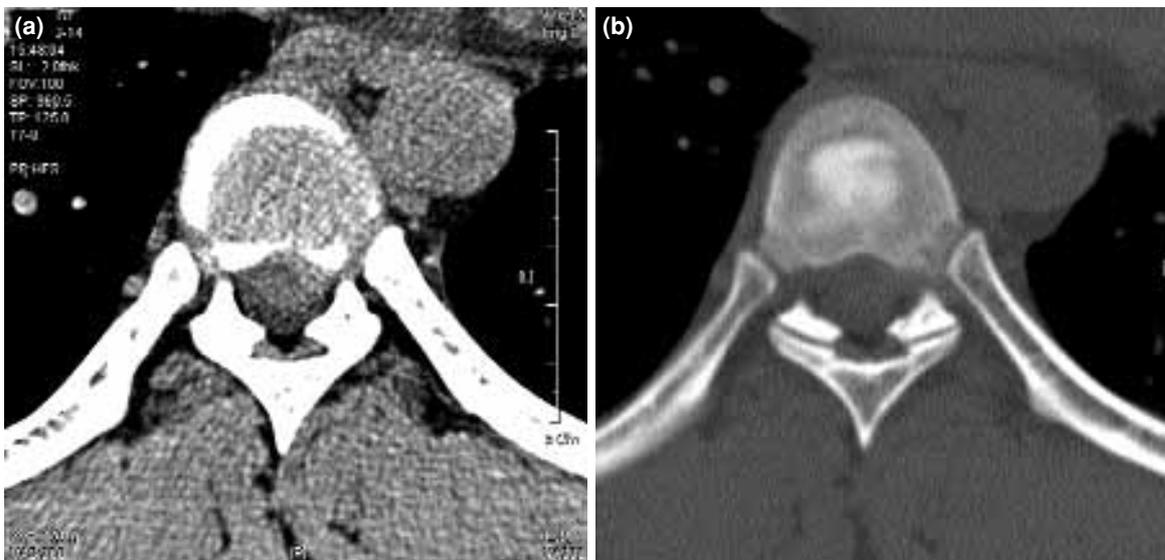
Computed tomography findings. (a) A preoperative image showing protruded disc herniation at T₇₋₈. (b) Postoperative image after removal of disc herniation.
